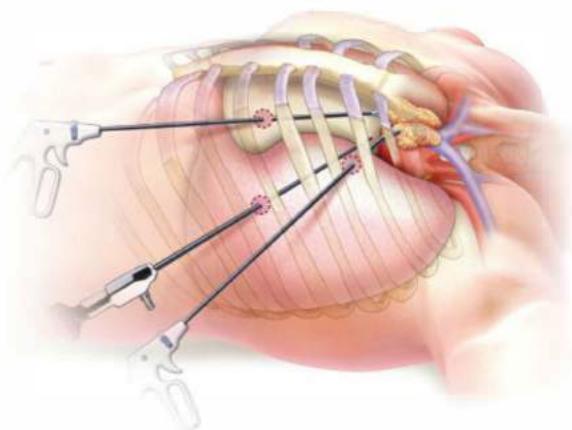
• Thoracic approaches should not be performed without positive localization studies. A. The image indicates positioning for a thoracoscopic approach. The patient is supine, with the ipsilateral arm elevated above the head to allow transthoracic access between ribs. B. Position placement for thoracoscopic trocars.
